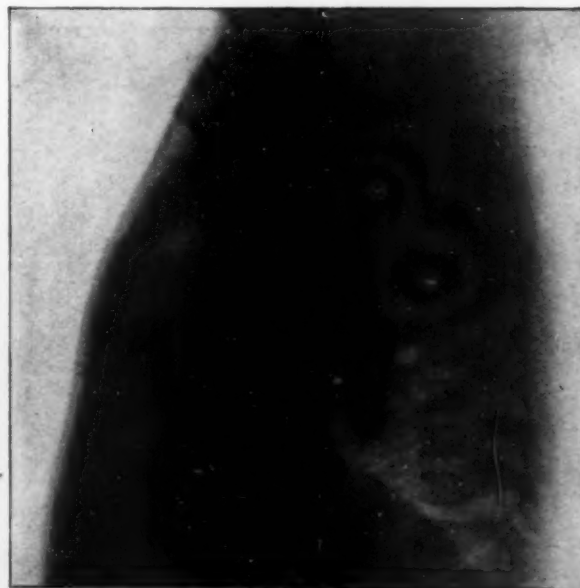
(Case 2).—Safety-pin in the esophagus, into which it had been regurgitated after a seven weeks' sojourn in the stomach as shown in Figure 3. Removed from esophagus by esophagoscopy through the mouth without anesthesia, general or local. (Roentgenogram by Dr. Willis F. Manges.)
